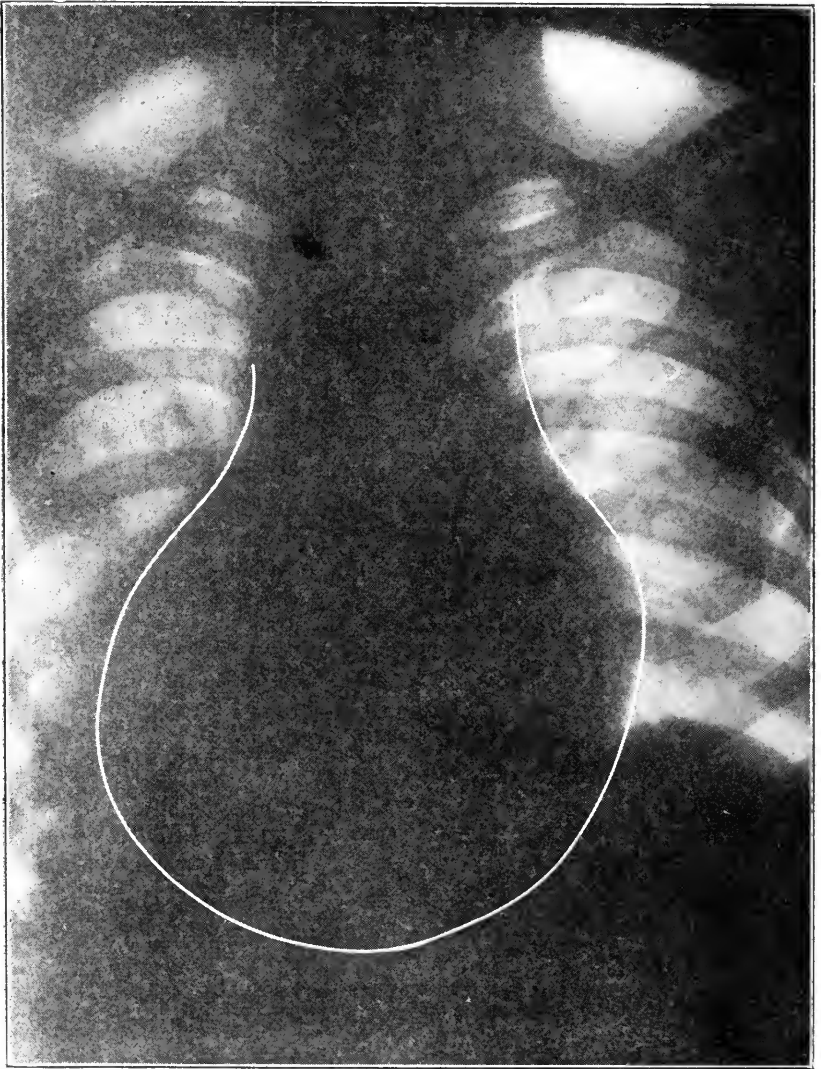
J. S., same heart as Fig. 1, radiographed about three weeks later, when the patient was greatly improved. (Courtesy Med. Clinics of N. A.)
